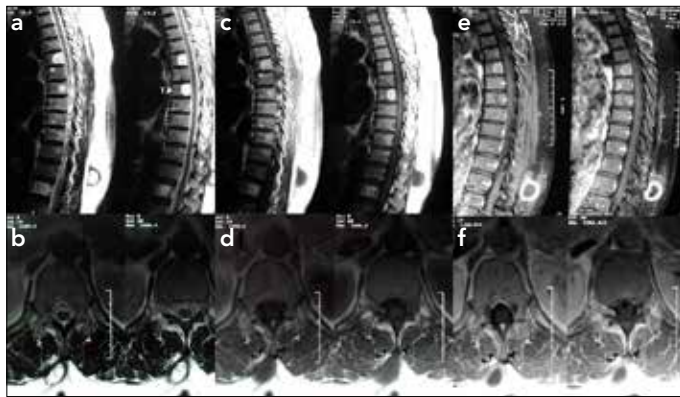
a-f. On T2-weighted MR images (a, b) a hyperintense cystic lesion with a hypointense rim is seen. On T1-weighted MR images (c, d), the whole lesion is hypointense. After IV-gadolinium injection (e, f), the cyst is hypointense with surrounding hyperintense parenchyma
